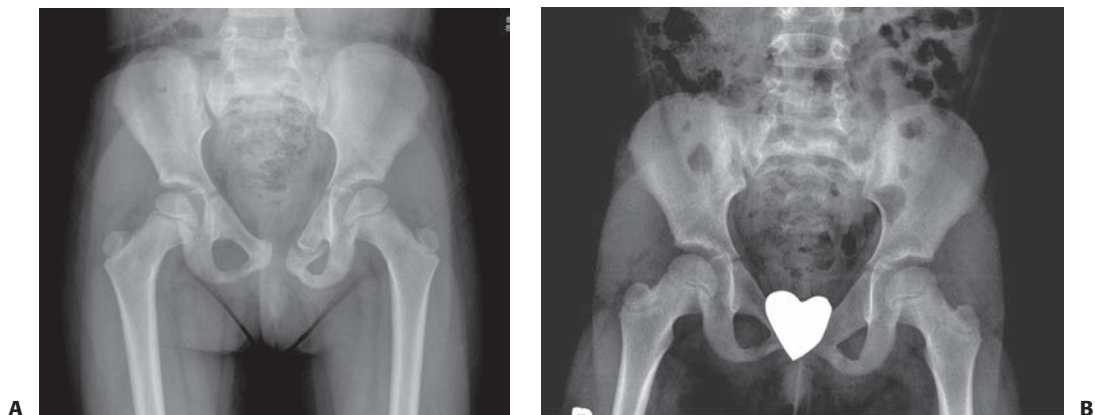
A: Stable superior pubic ramus fracture. The patient was allowed full weight bearing as tolerated. B: Radiographs show complete fracture union and remodeling.
